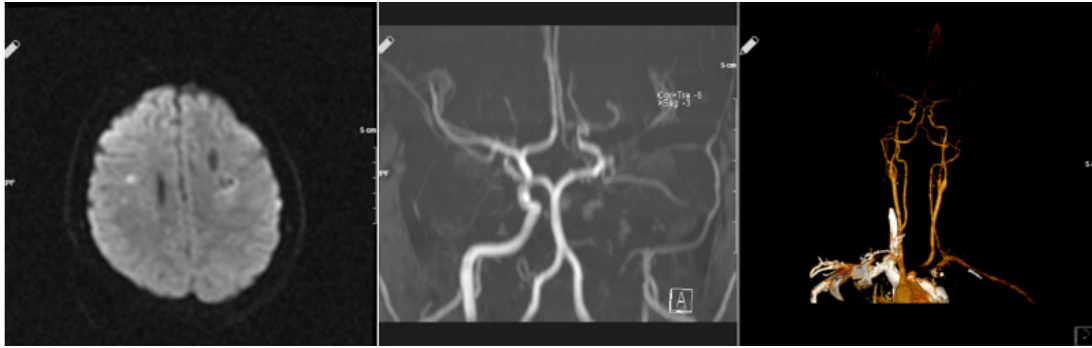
Left: Brain MRI DWI showed no infarction on the left side. Middle: Left ICA occlusion. Right: 10 days later, CT angiography shows normal left ICA.
